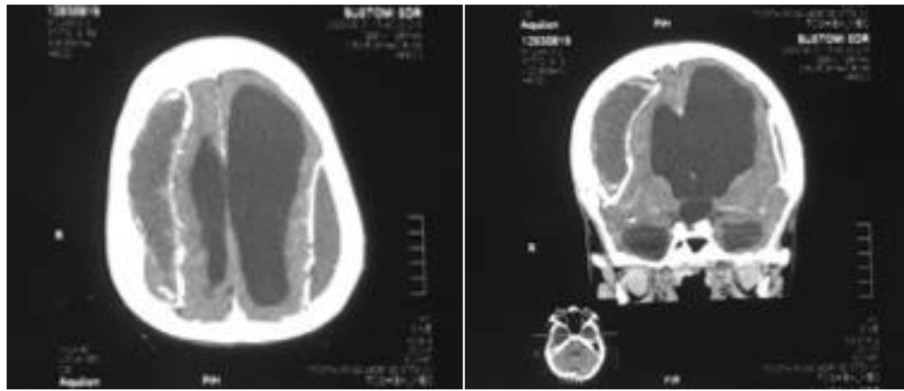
CT scan with contrast demonstrated hydrocephalus ex vacuo with CSDH in the bilateral FTP regions.
